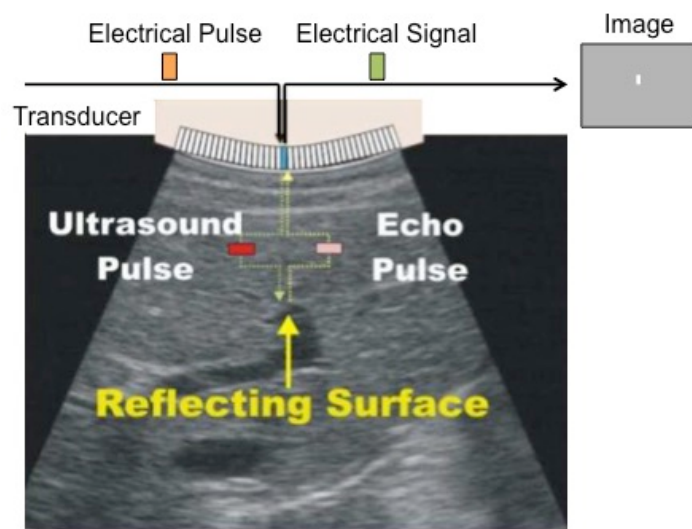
Functioning principle of ultrasound imaging. An electrical pulse is converted in an ultrasound pulse by the transducer. When a sound wave encounters a material with different acoustical impedance, part of the sound wave is reflected and detected by the probe as an echo, which is converted in electrical signal to form an image.
